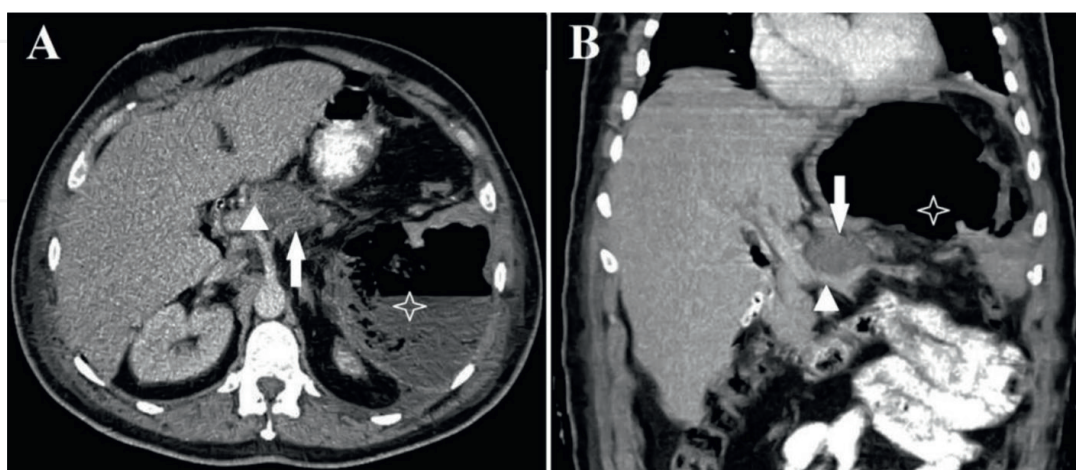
Computed tomography in a patient with primary PCE. (A) Axial image demonstrating pancreatic cystic lesion (arrow), thrombosis of splenic artery at its origin (arrowhead), and splenic abscess (asterisk). (B) Coronal image demonstrating patent splenic vein (arrowhead) along with the pancreatic cyst (arrow) and splenic abscess (asterisk).
